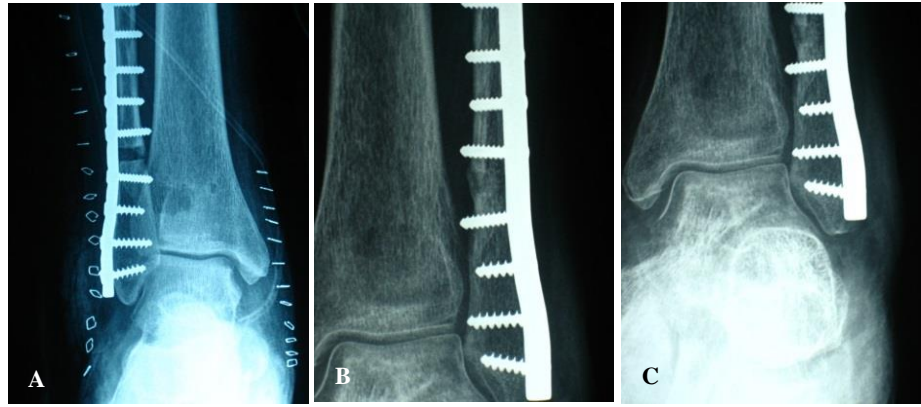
(A-C): Patient after surgical reconstruction with serial X-rays revealing anatomical alignment.
